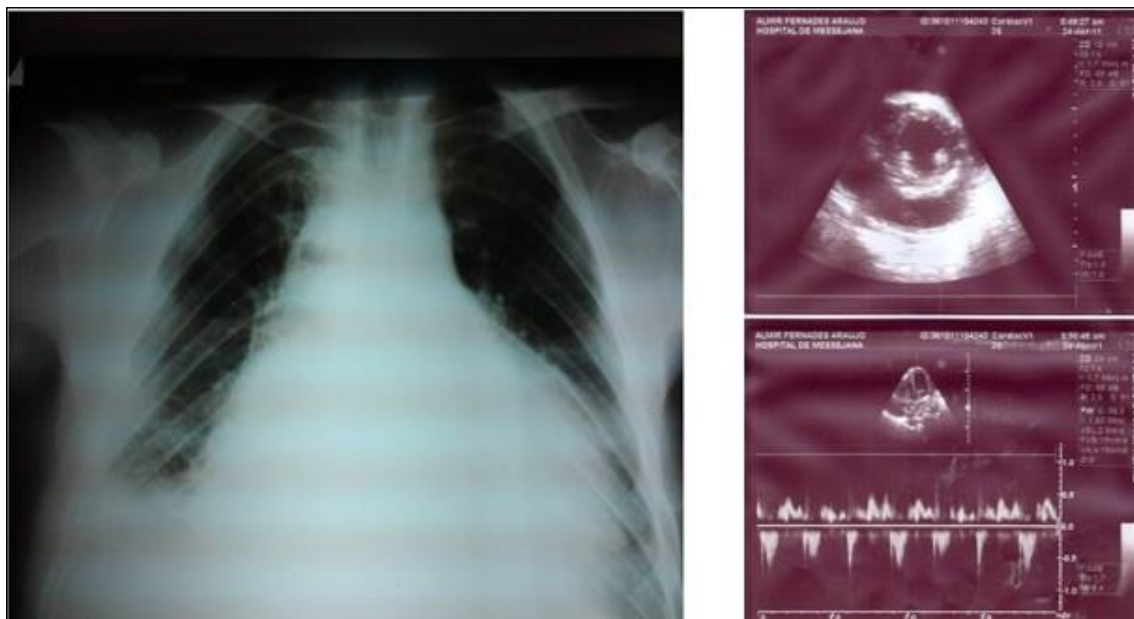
X-rays shows globular increase of the cardiac area with pleural effusion at the right. Echo showing pericardial effusion.
